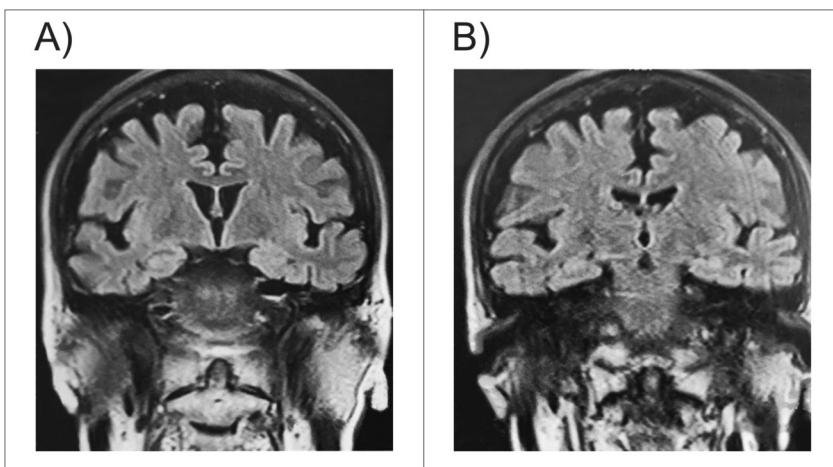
Cerebral MRI coronal cut not objectifying hippocampal atrophy
